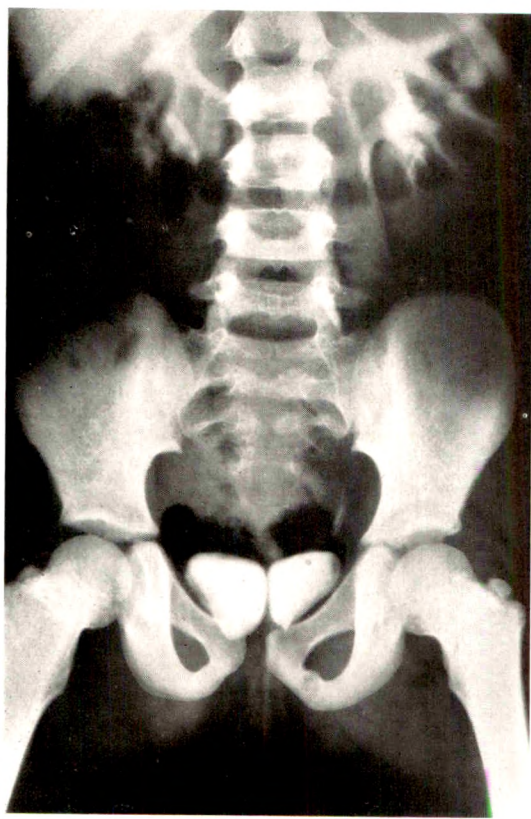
Roentgenographic demonstration of the double bladder following intravenous urography.
